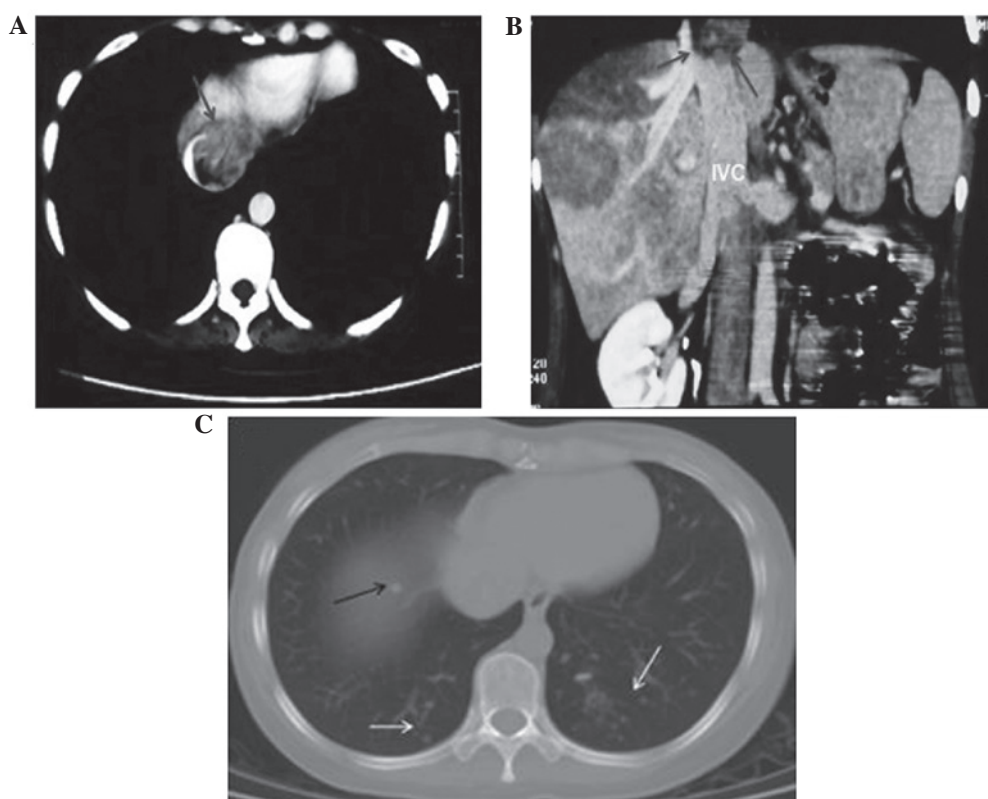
Abdominal CT prior to transcatheter arterial chemoembolization. Arterial phase of the CT scan, (A) cross-sectional scan and (B) coronal scan, presenting a well-defined, lobulated filling defect in the right atrium (arrows) and an irregular enhancement. (C) Chest CT scan exhibiting several solitary nodules (indicated by the black and white arrows) in the bilateral lower lobe lung, all of which were <0.5 cm in diameter. CT, computed tomography; IVC, inferior vena cava.
